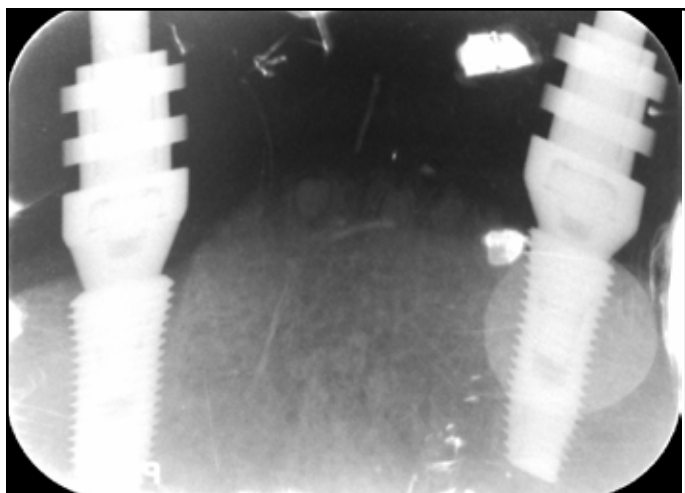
Intra-oral radiograph show distal tilting of left implant.
